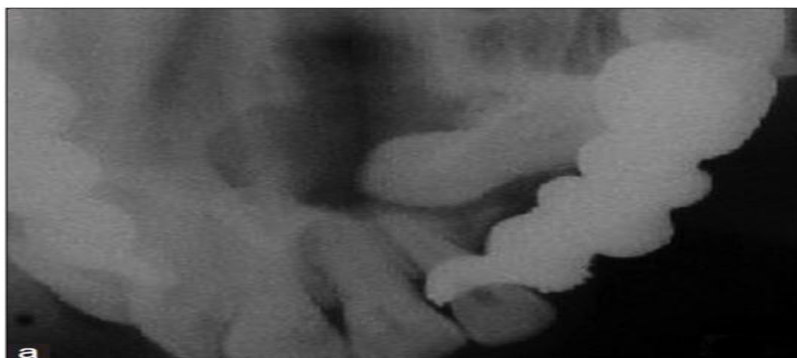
Maxillary occlusal radiograph showing unicystic type of ameloblastoma. (More et al, 2012)
